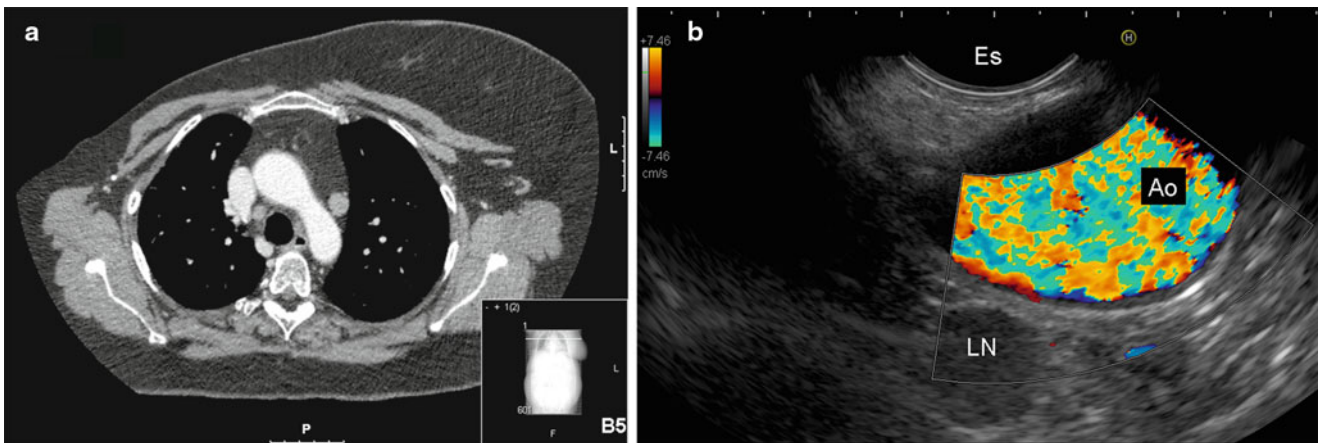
(a) Computed tomography of the chest demonstrating a para-aortal node (station 6). (b) Corresponding EUS image, the para-aortal node (*LN*) is seen transaortally (*AO*). *ES* esophagus
